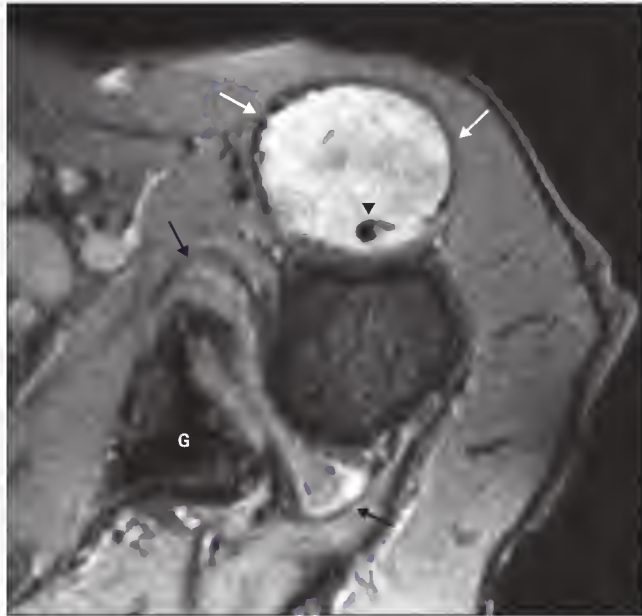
Axial gradient-echo magnetic resonance image of the shoulder in a patient with rheumatoid arthritis complaining of a mass. A large synovial cyst (white arrows) has dissected along the long head of the biceps tendon (arrowhead). Pannus (black arrows) is present in the glenohumeral joint along with marked irregular erosive change of the glenoid (G).
